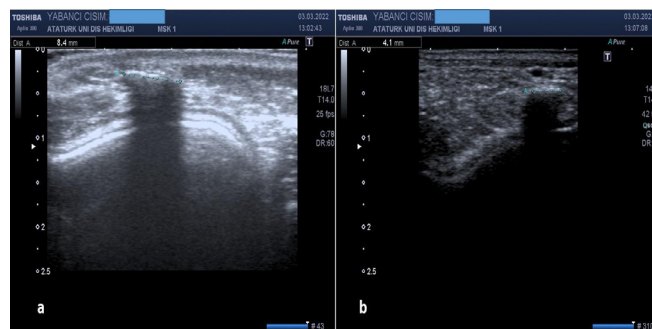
The ultrasonography of the metallic object revealed a hyper echogenic foreign body with posterior acoustic shadowing. a: Trans cutaneous-approach, b: trans-oral approach.
